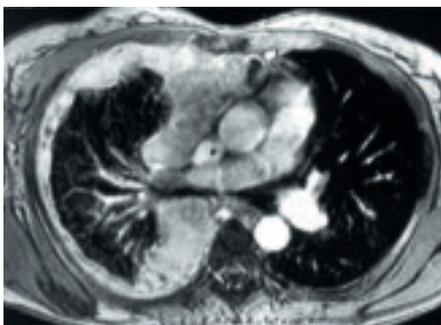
Diffuse malignant mesothelioma. In this CT scan, the pleura shows marked diffuse thickening by mesothelioma, with resulting encasement of the lung.
